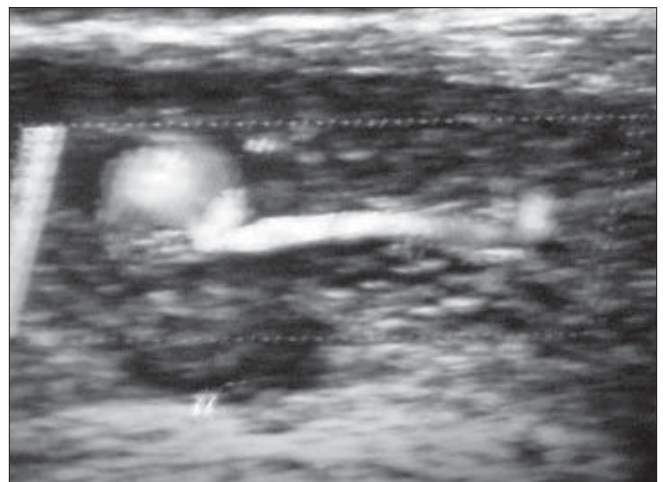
Duplex ultrasonogram of the cavernosal artery showing a pseudoaneurysm with flow
